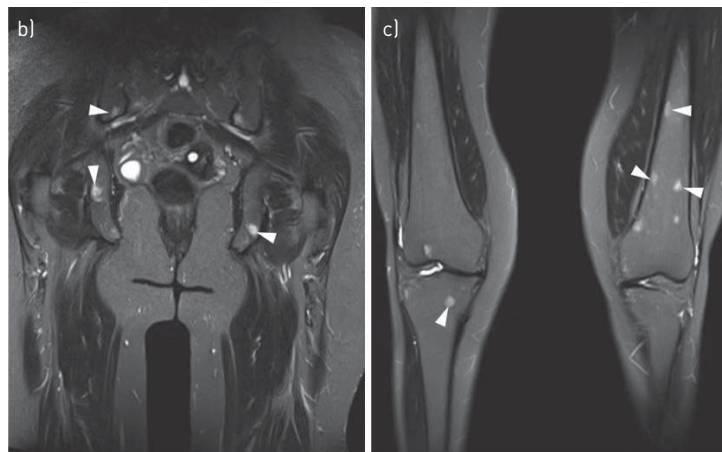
a) Baseline demographics, medication, pulmonary function, levels of angiotensin-converting enzyme (ACE) (normal range 12–68 U·L⁻¹) and soluble interleukin-2 receptor (sIL-2R) (normal range <477 pg·mL⁻¹), extrapulmonary physician organ severity tool (ePOST), and whole-body magnetic resonance imaging (WB-MRI) findings of all 24 patients with sarcoidosis. Data are presented as n, mean (range) or n (%). FVC: forced vital capacity; TLC: total lung capacity; FEV₁: forced expiratory volume in 1 s; DLCO: diffusing capacity of the lung for carbon monoxide. Portions of coronal WB-MRI (Short Tau Inversion Recovery images) show b) multiple osseous lesions probably related to sarcoidosis in the pelvis (arrowheads) and c) around both knees (arrowheads) in a 53-year-old female.
